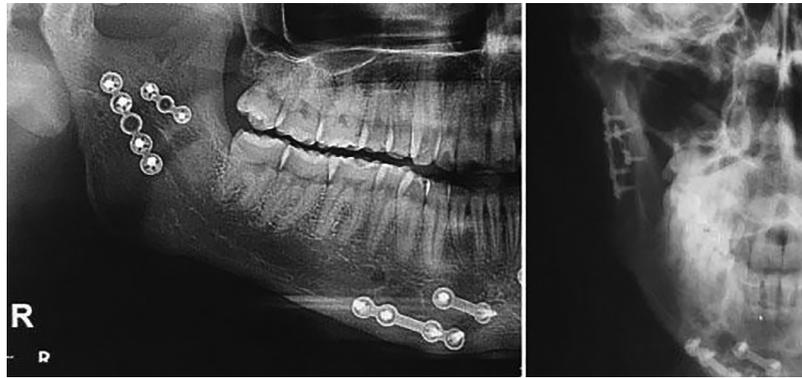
One-year follow-up radiograph of the endoscope-assisted open reduction and internal fixation (EAORIF) approach.
